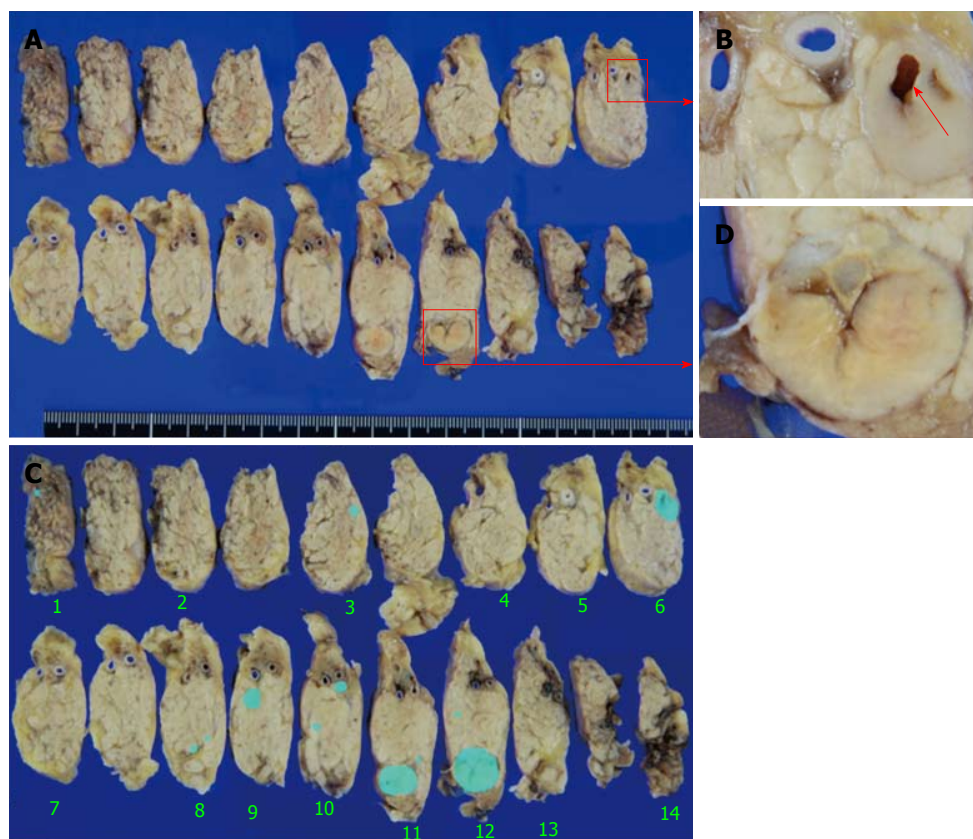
Macroscopic findings for the resected pancreas. A: The main cystic lesion has morphologically changed to a 13-mm nodule (red square C). The microtumor in the pancreatic body on which EUS-FNA was performed was separate from the main lesion; B: A scar from EUS-FNA is evident in the microtumor (red arrow); C: The main nodule shows internal scarring; D: The main lesion and two microtumors detected on EUS, and another 11 new microtumors (1-3 mm) (blue areas). EUS-FNA: Endoscopic ultrasound-fine needle aspiration.
